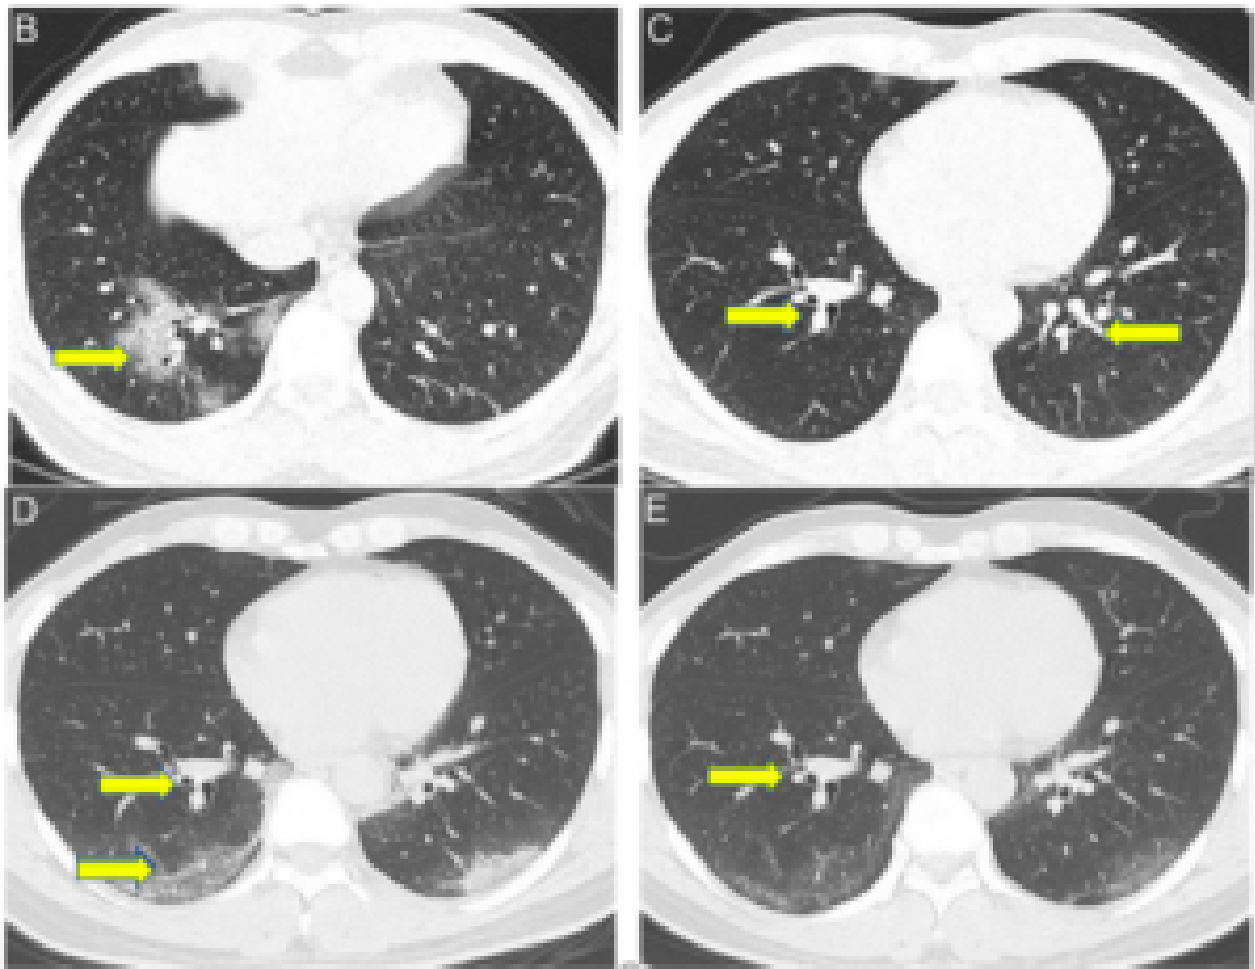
B and C- Chest CT showed multiple ground-glass infiltrates (yellow arrows) in right lower lung field (admission day). D- Repeat chest CT displayed larger areas of ground-glass opacities (yellow arrows) in both lower lungs with a peripheral distribution (day 8). E- Repeat chest CT showed remission of lung lesions, with reduced density of ground-glass opacities (day 17).¹
